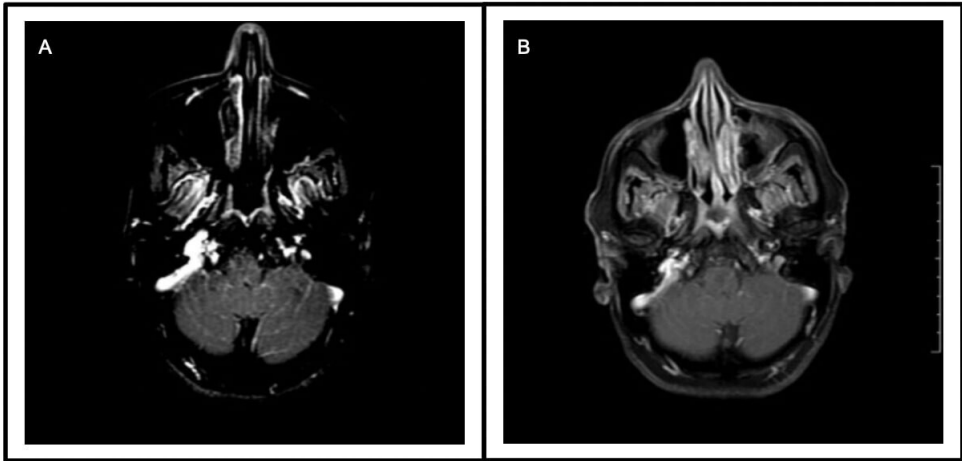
MRI findings of selected patients. Axial T1-weighted postcontrast MRI of patient 2 shows subtle leptomeningeal enhancement in the posterior fossa (A), which reduced on follow-up with treatment (B).
